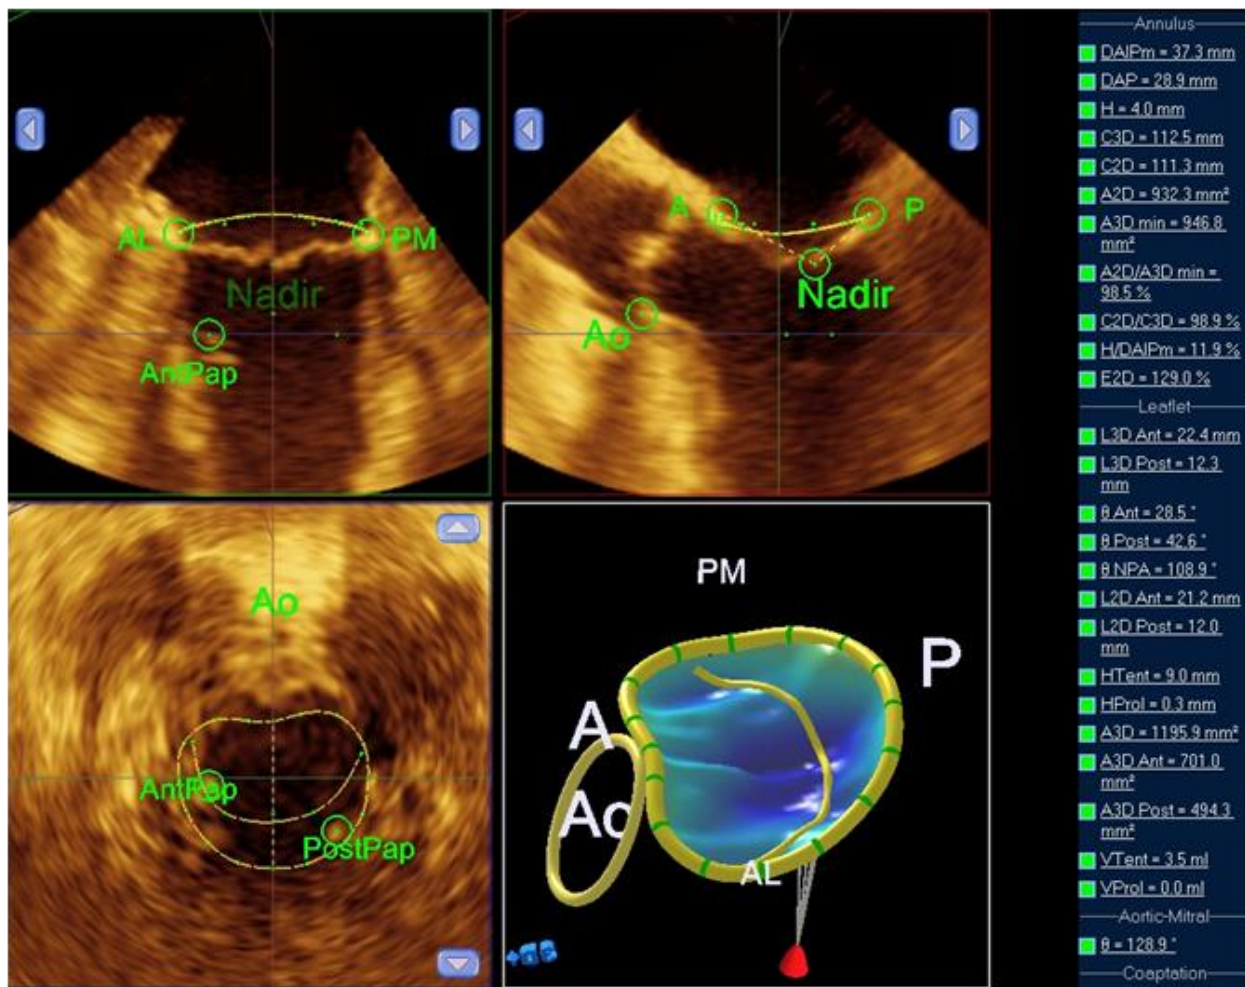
Quantitative assessment of mitral valve morphology. Mitral valve quantification software used for off-line post-processing of 3-dimensional echocardiography images is capable of providing additional volumetric information on the mitral valve morphology otherwise unavailable with most other imaging modalities.
